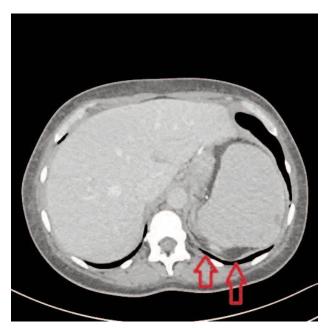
CT scan of the abdomen cavity: enlarged spleen with disseminated ischemic lesions (red arrows)
